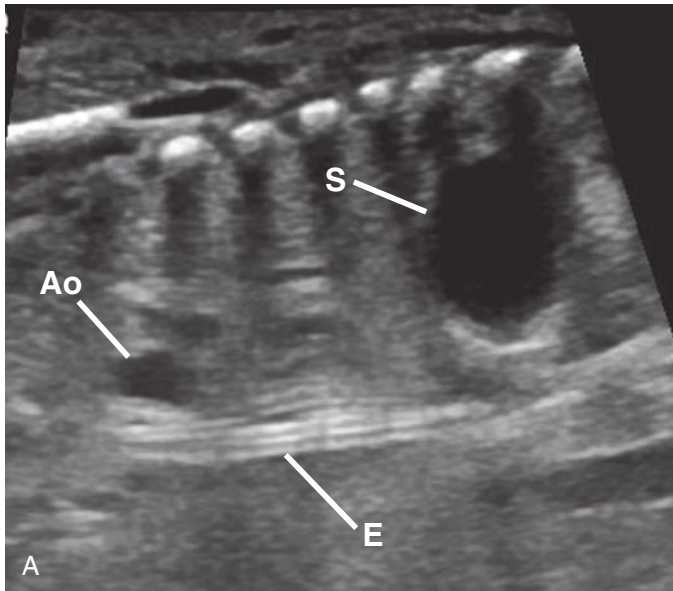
Coronal (A) and transverse axial (B) sonograms demonstrating the esophagus (E). The serosa and lumen appear hyperechoic, and the muscular wall is hypoechoic. Distally, the esophagus lies anterior to the descending aorta (compare Fig. 8-83). Proximally, it lies posterior to the transverse aorta (in B) and medial to the ascending aorta (in A). Ao, aorta; S, stomach; SVC, superior vena cava.
